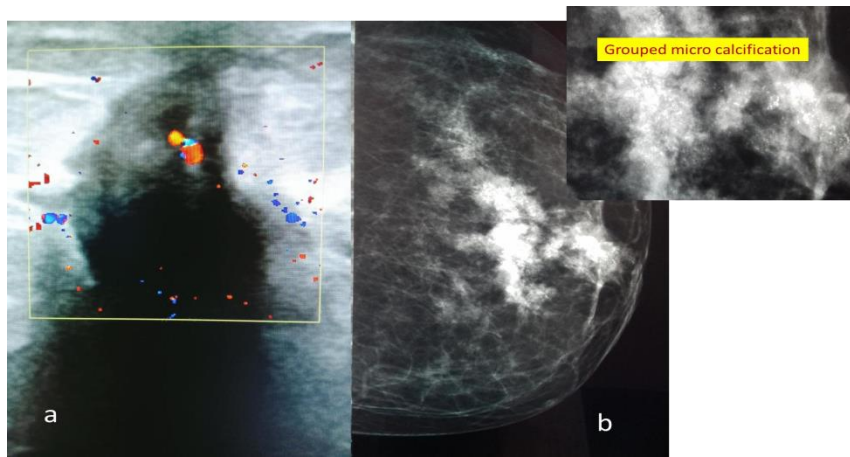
Case 1: (a) ultrasound of the left breast shows ill-defined hypo echoic speculated mass with significant internal vascularity, (b) mammography of the left breast shows ill-defined high dense speculated mass lesion with suspicious grouped micro calcifications in left retro areolar region.
